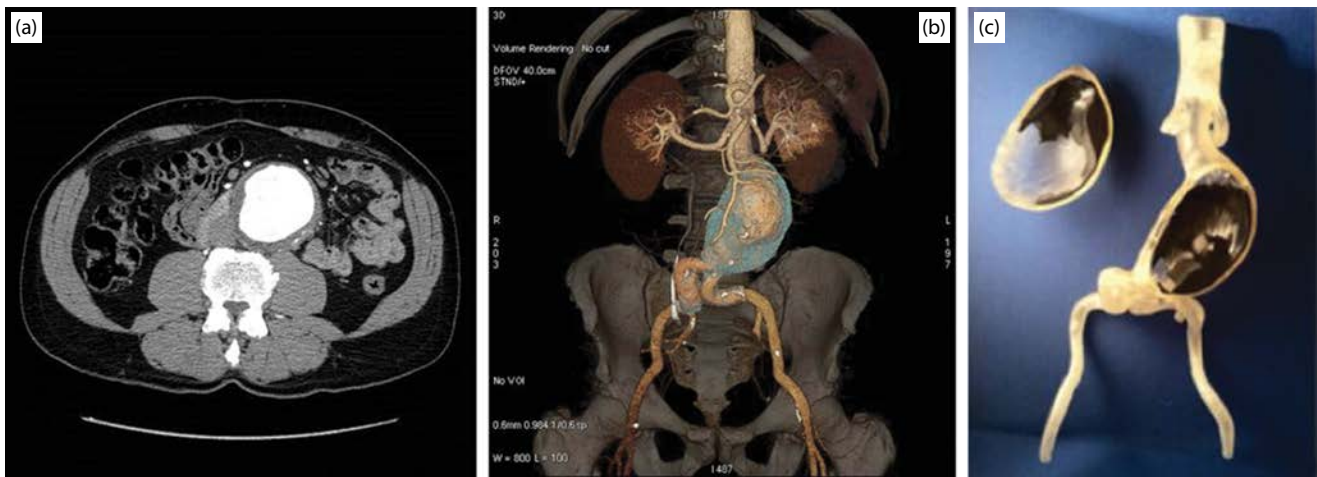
(a) 2D contrast-enhanced axial computed tomographic image of abdominal aortic aneurysm. (b) 3D reconstruction of aortic aneurysm. (c) Model of aneurysm with translucent outer aorta wall that has been sectioned in the coronal plane to reveal internal anatomy with the calcifications in white and mural thrombus in black.
